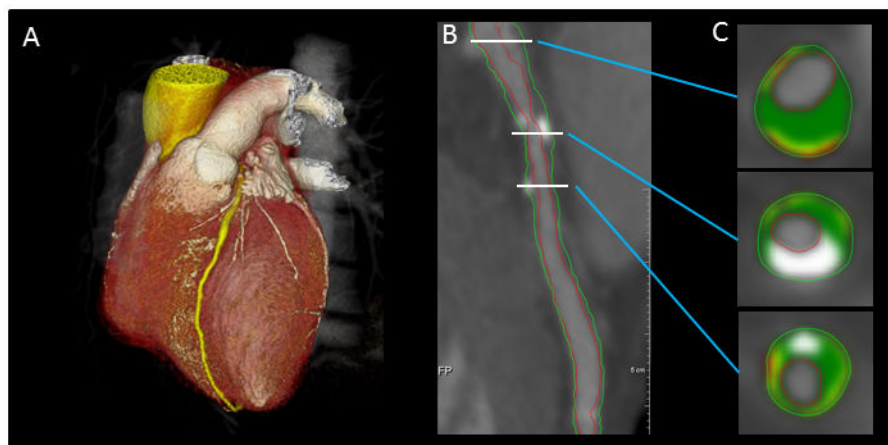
Coronary CT angiography: Volumetric plaque analysis
